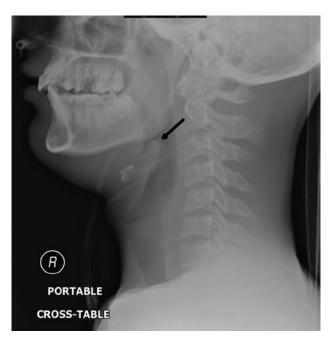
Neck radiograph of the epiglottitis showing thumb sign. Case courtesy of Dr Andrew Ho, Radiopaedia.org, rlD: 22906.
